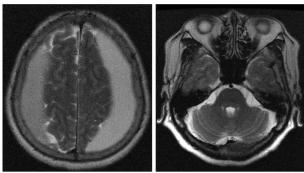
Preoperative T2-weighted axial magnetic resonance images of the brain show a bifrontal subdural hematoma without abnormal findings in the posterior fossa.
